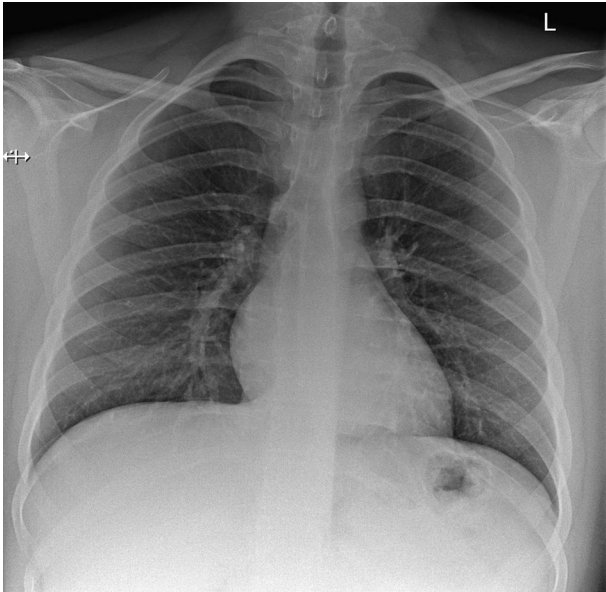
Normal chest X-ray. It is useful to have a normal chest X-ray as a reference when looking at ICU X-rays as this allows the eye to detect abnormalities more easily.
